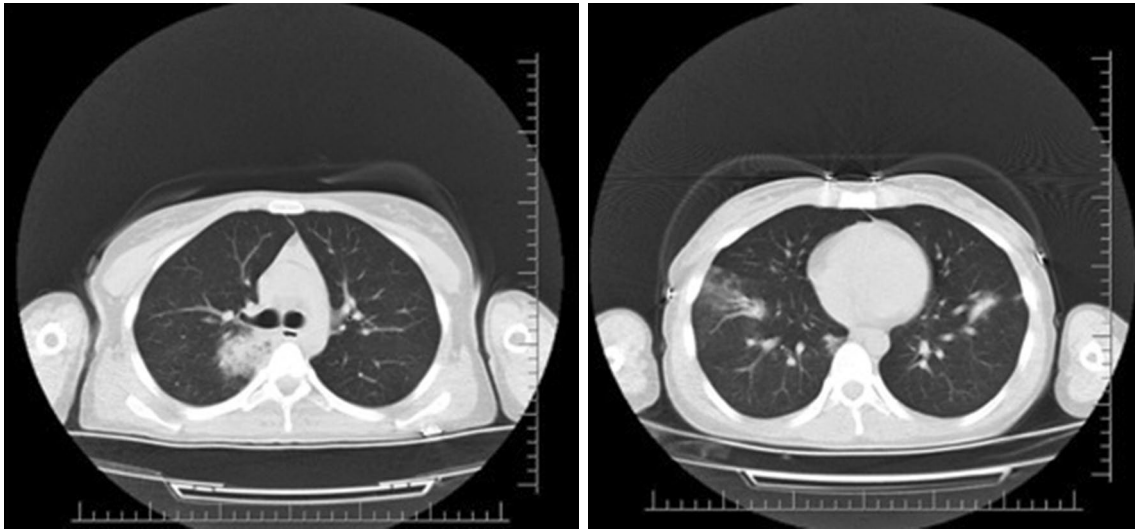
Thorax computed tomography images.
